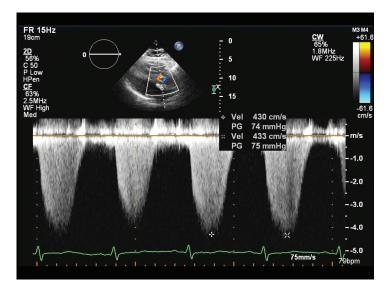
Transthoracic echocardiography continuous wave Doppler of the tricuspid regurgitant velocity consistent with elevated right ventricular systolic pressure.
